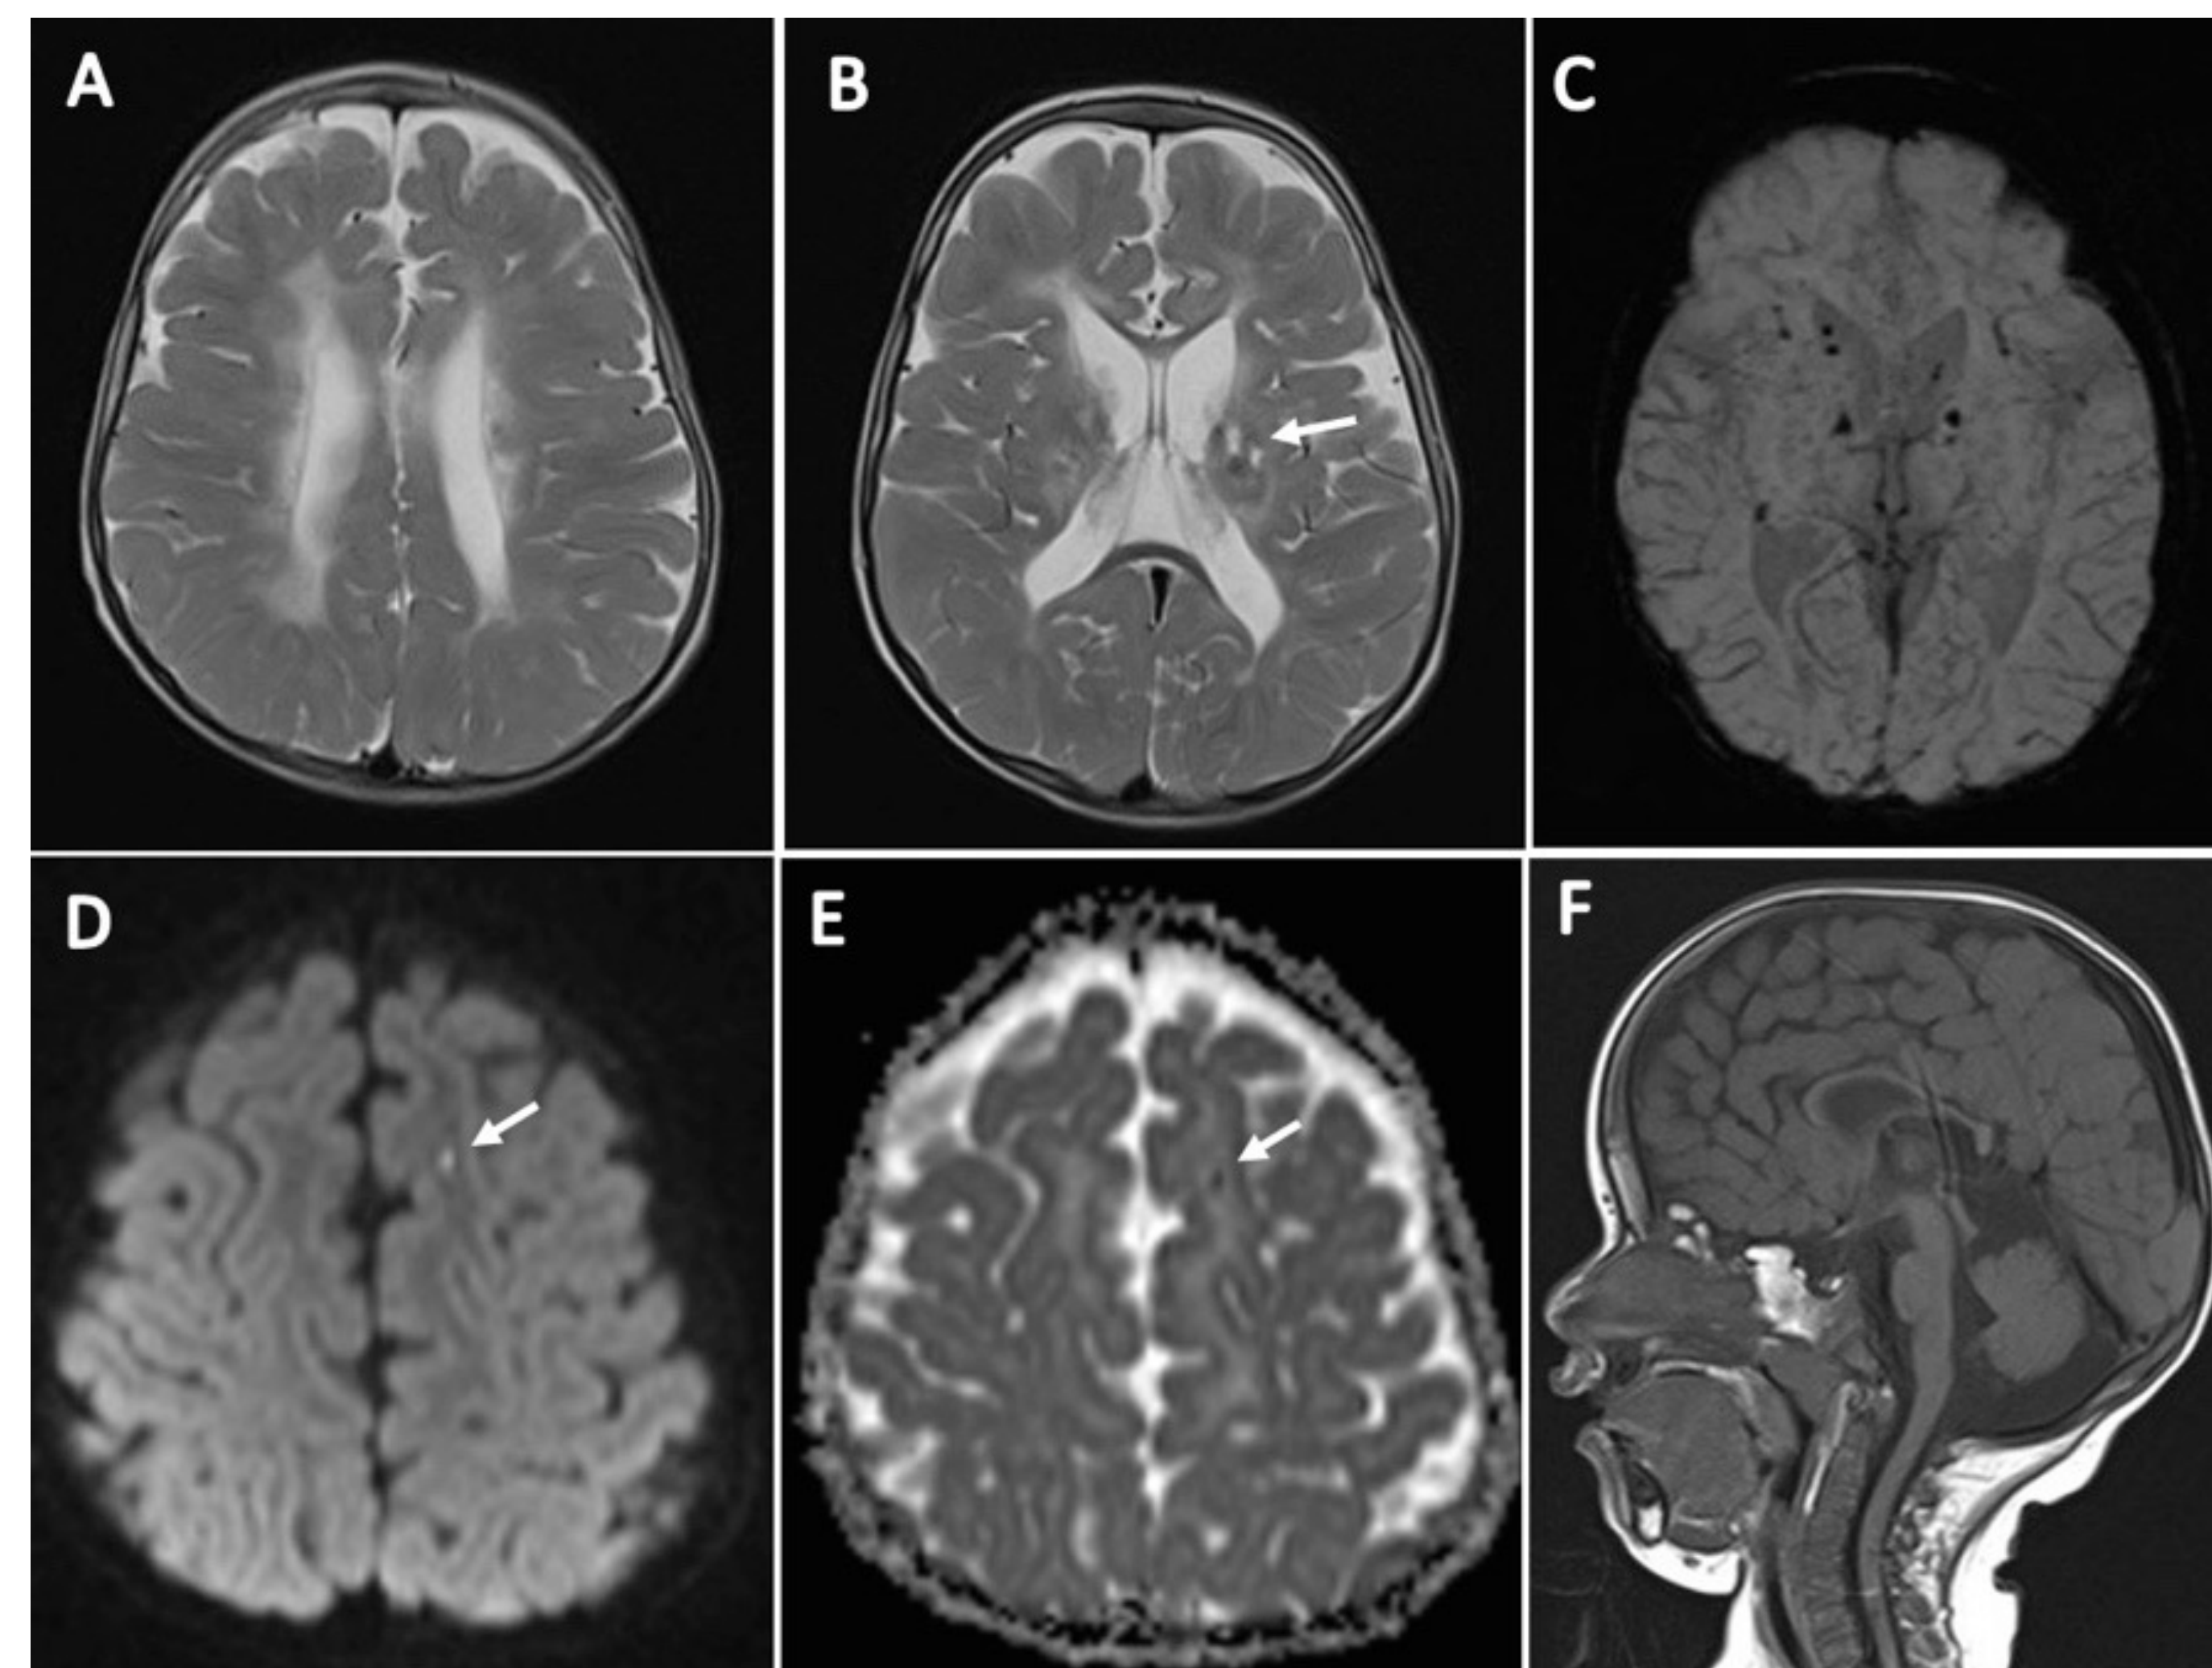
MRI of patient 1 at 18 months of age:
